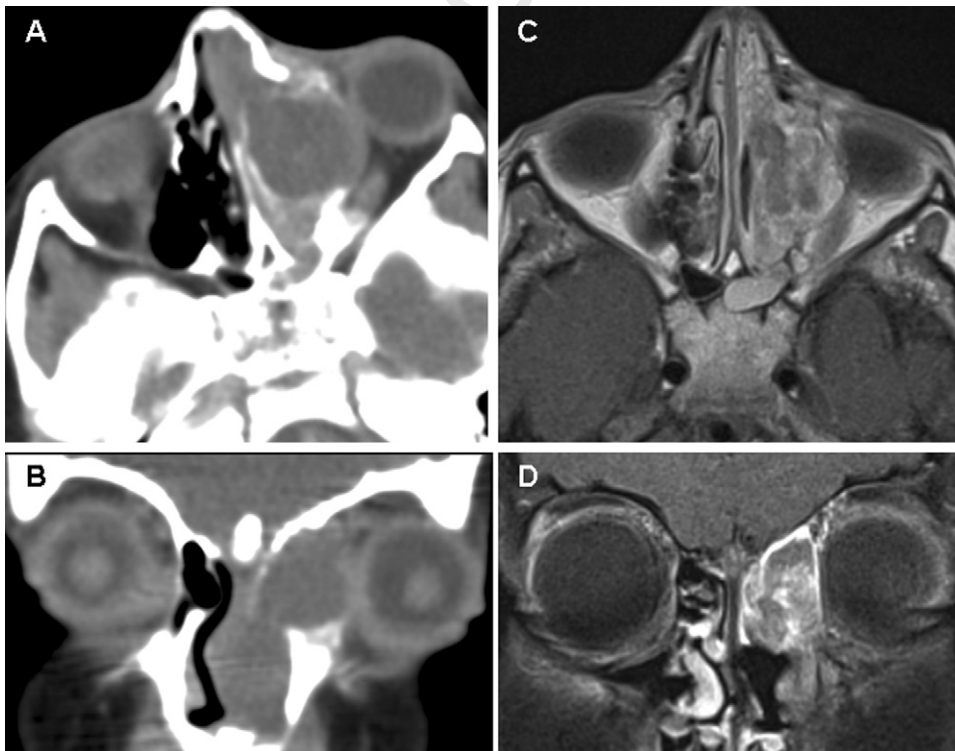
(A, B) Contrast-enhanced CT scan: an expansile lesion involving ethmoid sinus with displacement of eyeball and edge enhancement was attested. (C, D) Axial and coronal MRI T1 sequence postgadolinium showed the edge enhancement of lesion confined to the sinus ethmoidalis, adjacent to the fovea ethmoidalis. No invasion of orbit, skull base or contralateral side was encountered. Maximum size was 2.6 cm × 1.2 cm × 1.9 cm.
